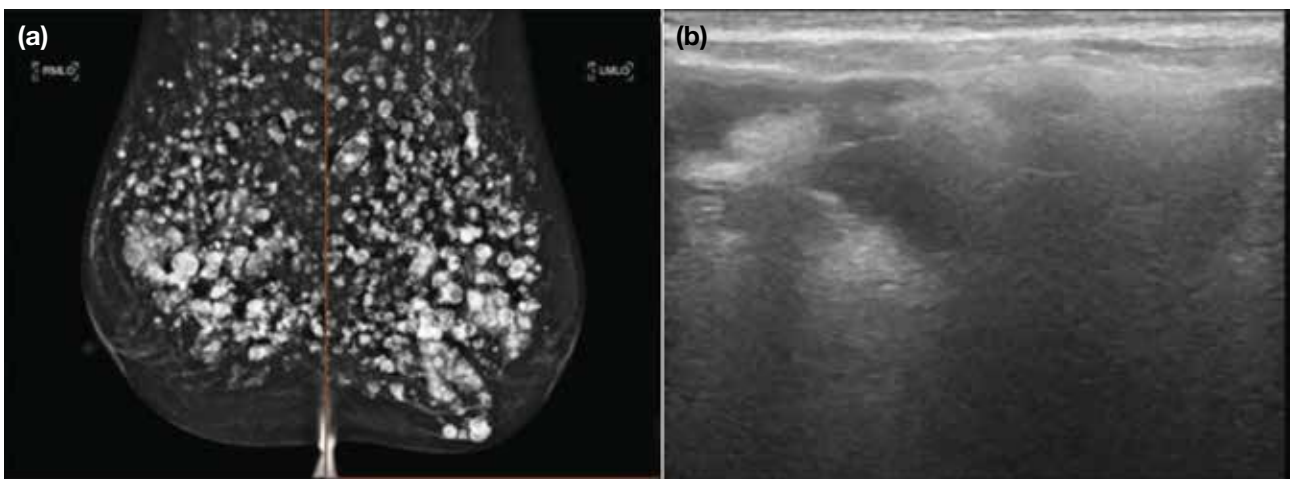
History of freehand silicone injection. (a) Mammography showing multiple dense and calcified nodules in both breasts representing the injected silicone and calcified granulomas in both breasts. (b) Ultrasonography showing silicone injection casting dense shadowing, known as the ‘snowstorm’ appearance.
